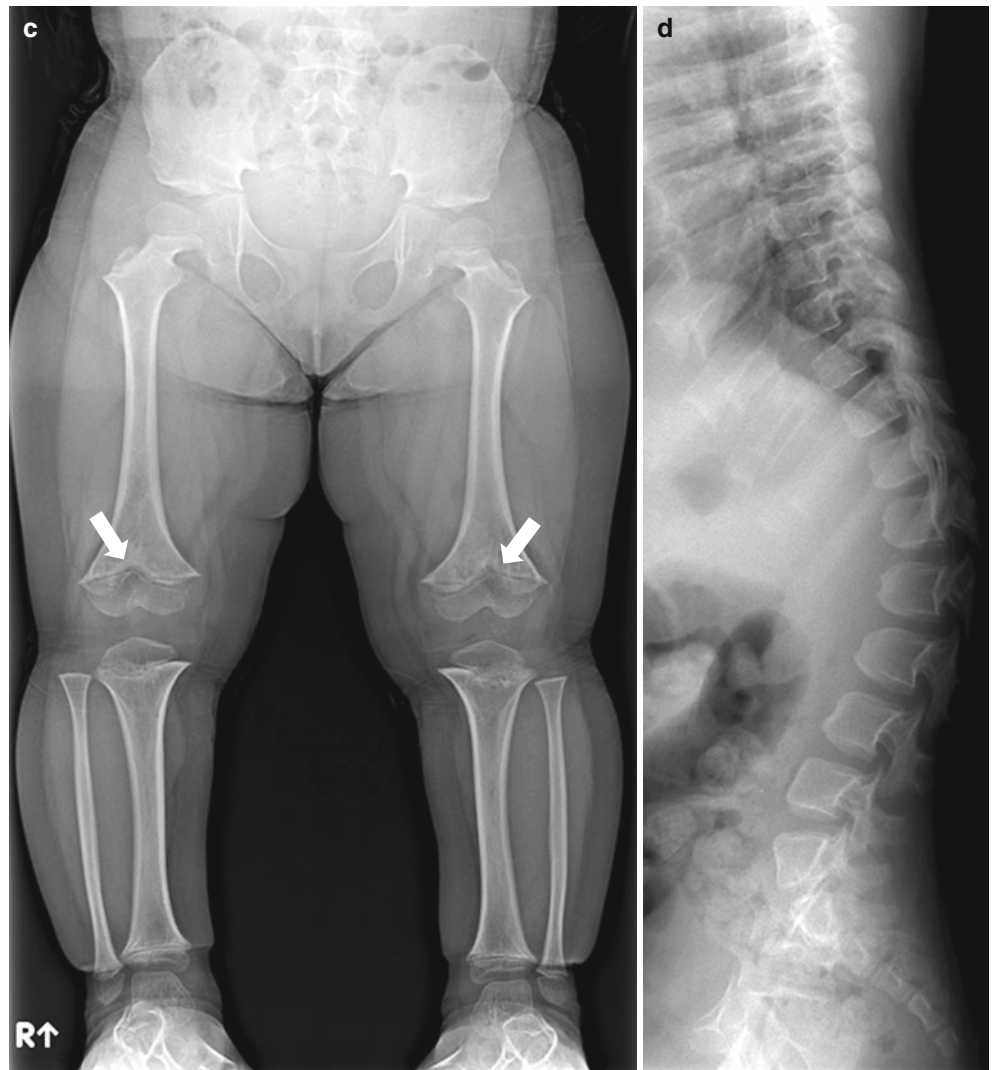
Achondroplasia: older child.* (a) Skull lateral view of a 3-year-old boy shows macrocephaly and narrow skull base with J-shaped sella. Note the frontal bowing and midface hypoplasia. (b) Sagittal T1-weighted image of the same patient demonstrates hydrocephalus and narrow foramen magnum (arrows). (c) Lower extremity radiograph of a
